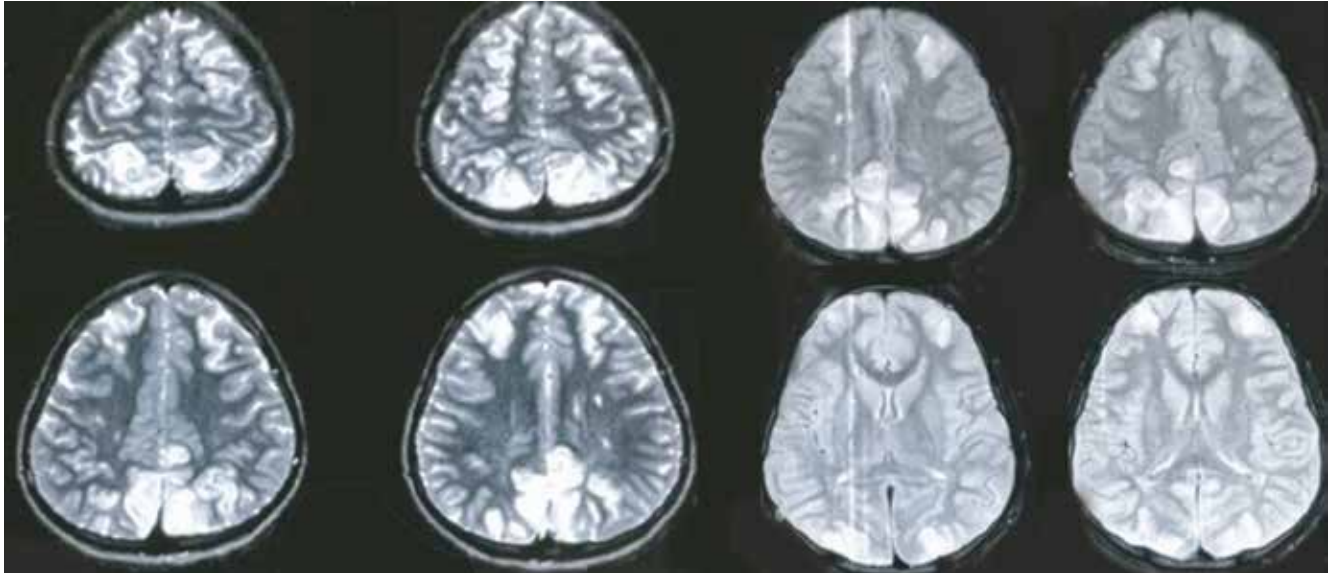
Magnetic resonance imaging; (a) T2W sequence showing hyperintensities in bilateral parietal, frontal and occipital areas. (b) FLAIR sequence showing hyperintensities in both anterior and posterior areas of bilateral parietal, frontal and occipital areas.
